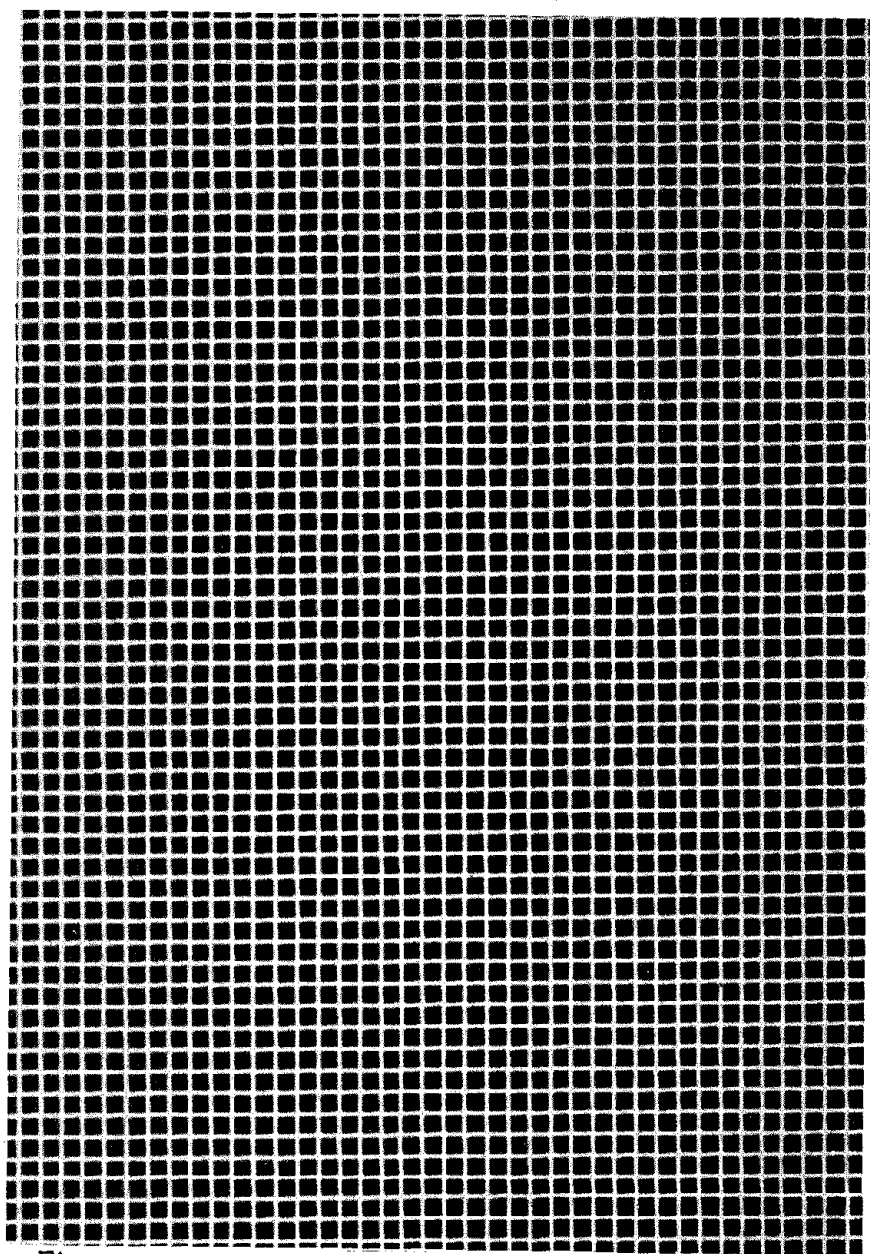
Wire mesh radiograph, poor screen contact.
